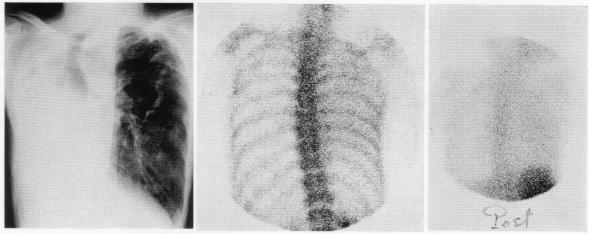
A 60-year-old female with old pulmonary tuberculosis and mitral regurgitation. She was admitted to the hospital with dyspnea and right omalgia. Chest radiograph (Left) shows opacification in the entire right hemithorax. Posterior view from a bone scan (Middle) demonstrates slightly increased accumulation of ^{99m}Tc-MDP in the right hemithorax. ⁶⁷Ga scan (Right) also depicts slight uptake in the right hemithorax. She was proven to have benign pleural effusion due to cardiac failure, and it disappeared following treatment with diuretics and digitalization.
